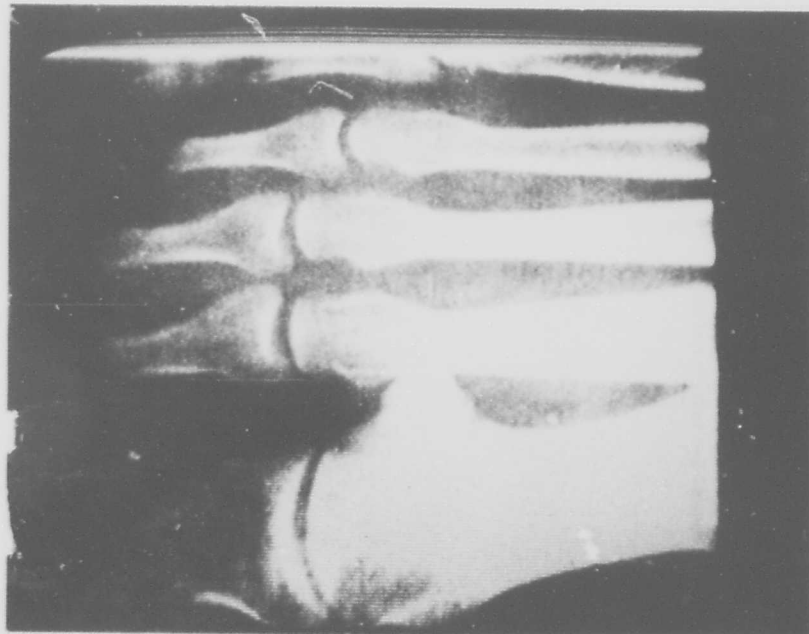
Transmission via uhf of x-ray negative of metatarsal bones.
